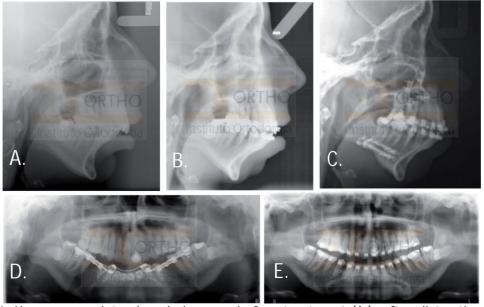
X-ray exams: lateral cephalograms before treatment (A.); after distraction (B.); after bimaxillary surgery (C.); ortopantomography immediately after distraction (D.); ortopantomography one year post distraction (E.).
